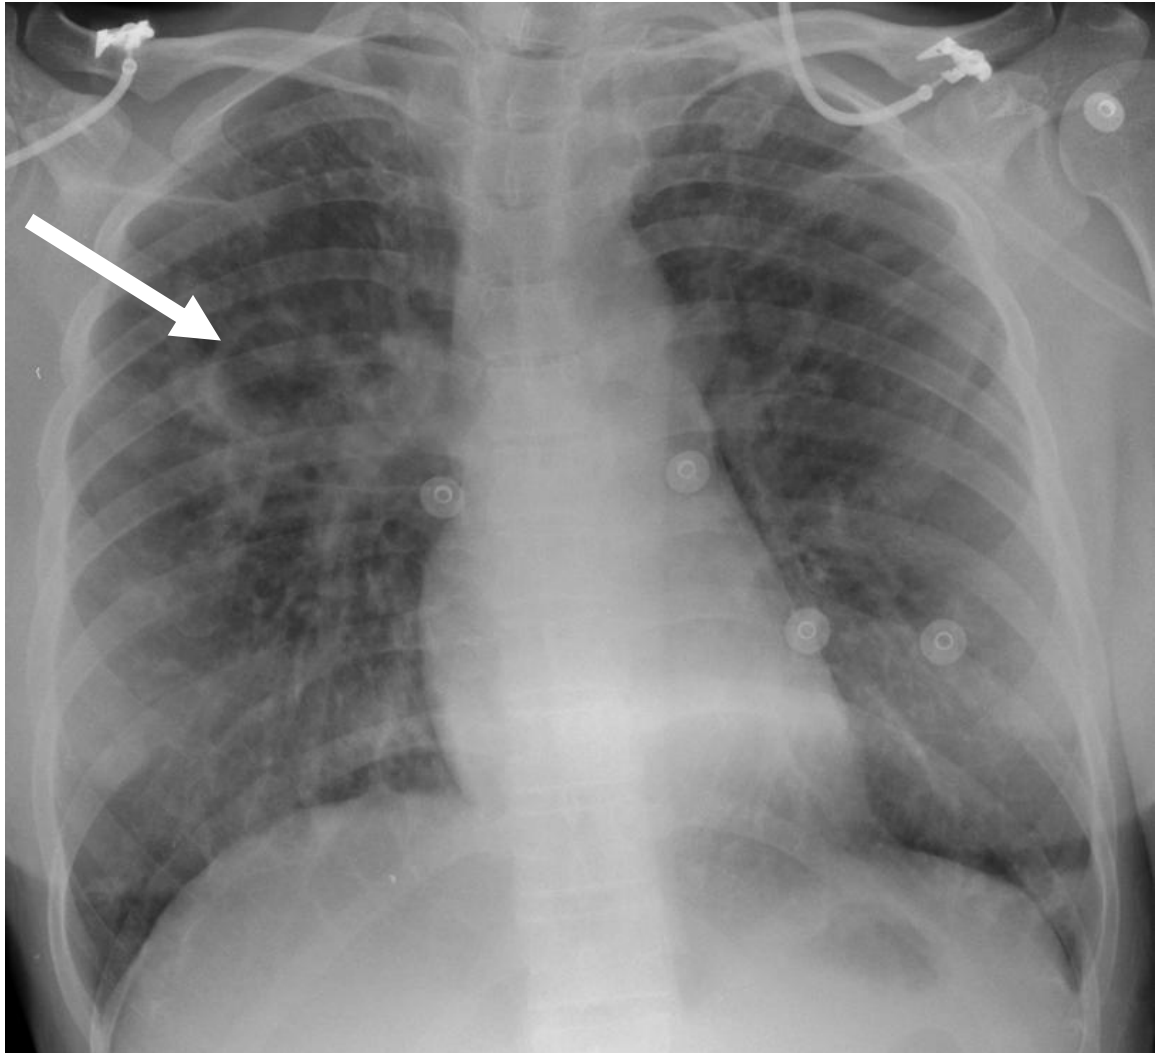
Chest x-ray demonstrating cavitation (indicated by arrow) in the upper right lobe and consolidation. Courtesy of Dr. Marc Lipman, Royal Free Hospital, London
